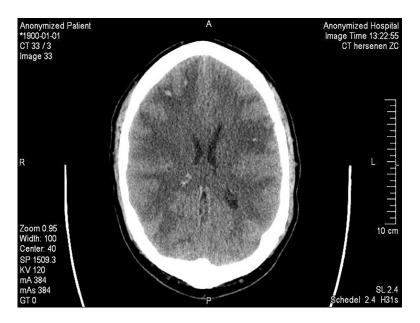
Transversal cerebral CT scan showing multiple juxtacortical microbleeds, which may be compatible with venous hemorrhagic infarction.
